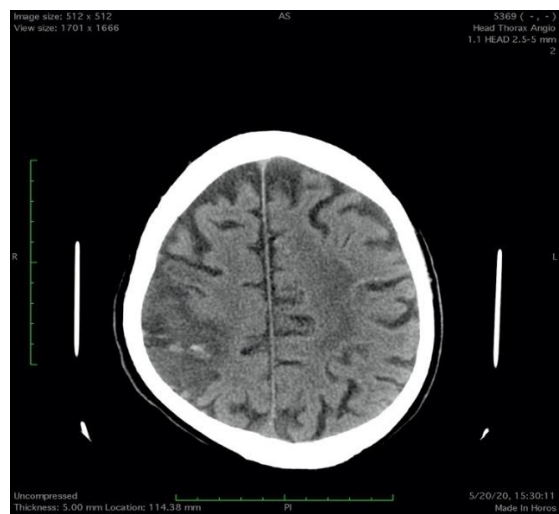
CT scan of brain was detected acute haemorrhagic infarction (Hemorrhagic transformation after vein cortical thrombosis and cerebral infarction) in the right parietal lobe.
